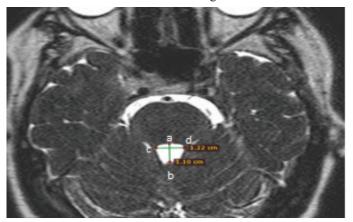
MRI of the brain at the level of fourth ventricle in male showing the transverse width and AP length measurement of the fourth ventricle in cm. The green lines indicate the AP length and transverse width.
